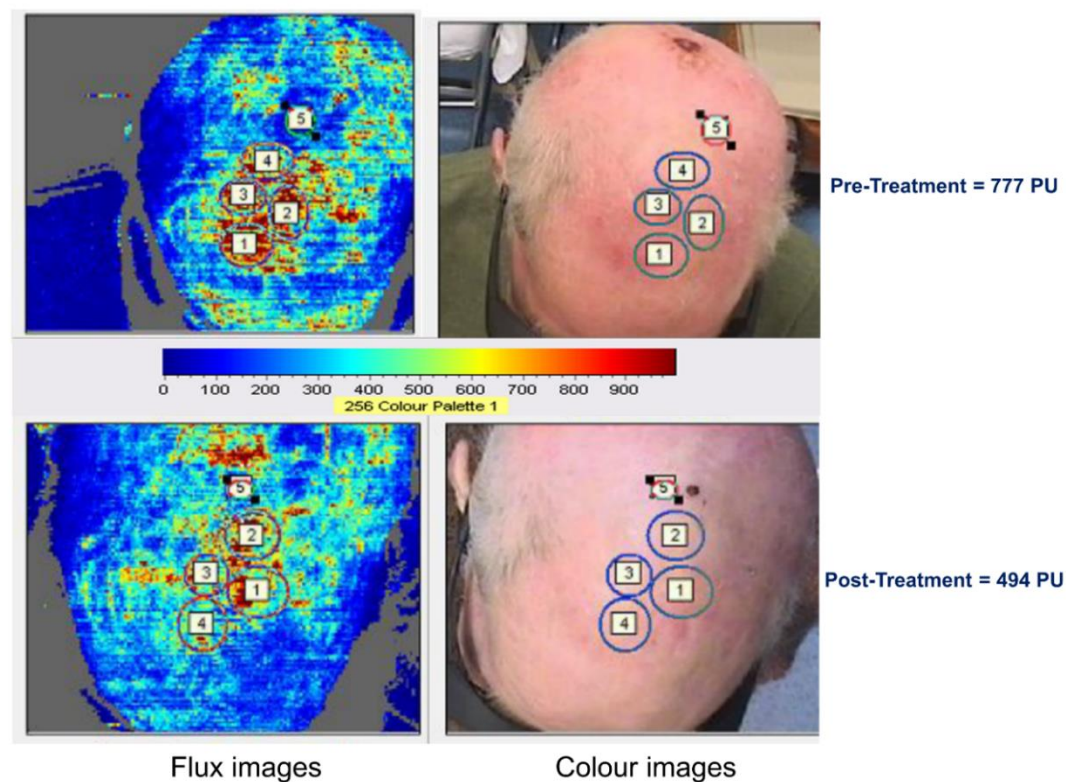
Images from laser Doppler imaging of Patient 25 who had a partial reduction in ML-SADDLE score post-treatment
